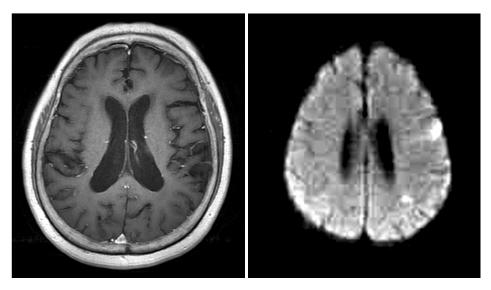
Brain MRI shows acute infarction in left precentral gyrus and left parietal lobe.
